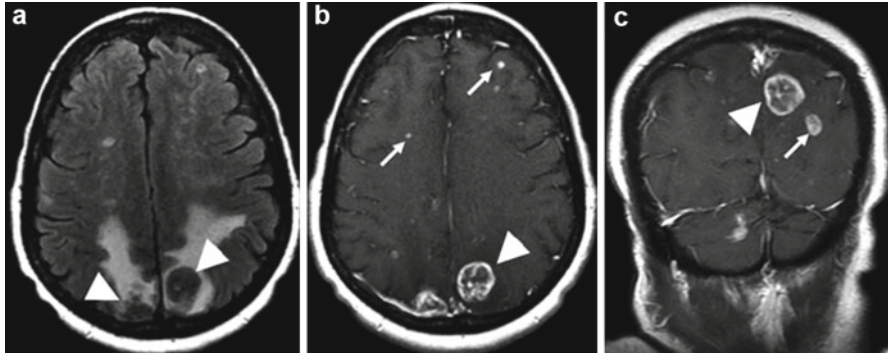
Example of metastatic disease. (a) T2 FLAIR; extensive vasogenic edema surrounds two posterior parietal metastases (*arrowheads*). (b, c) Post-gadolinium T1WI; examples of target lesions that are measurable (*arrowheads*) and nontarget lesions (*arrows*) that are not measurable, but should be followed
